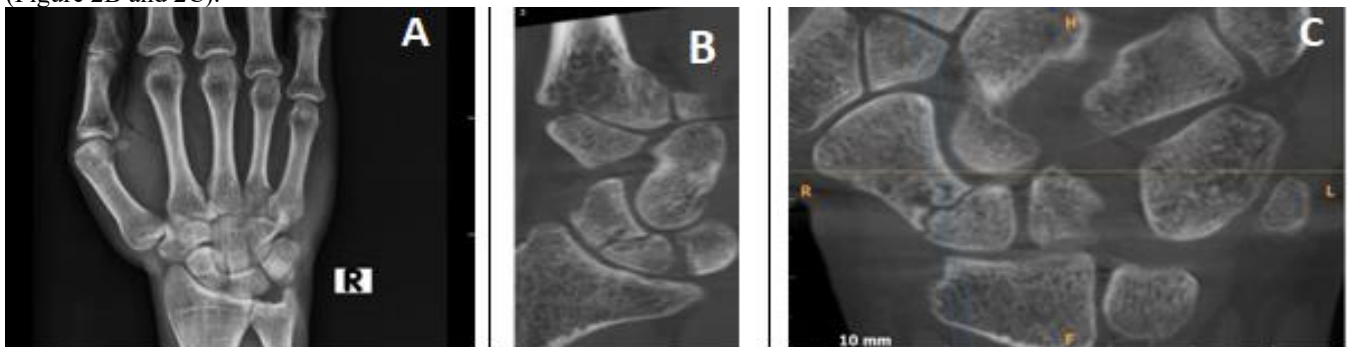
Radiography of the hand showing an occult fracture (A); CBCT images (B,C) demonstrating a displaced unhealed scaphoid fracture with avascular necrosis.
